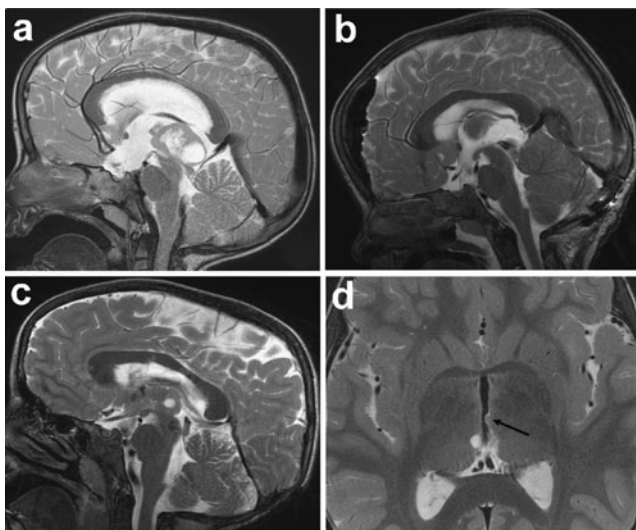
a Sagittal preoperative T2-weighted MRI showing a cerebral mass with cystic portions located in the pineal region. b Sagittal postoperative T2-weighted MRI demonstrates complete resection. c Local tumor recurrence 36 months after complete resection. d Axial T2-weighted MRI obtained after proton beam therapy. A small residual tumor is seen only on axial slices (arrow)
